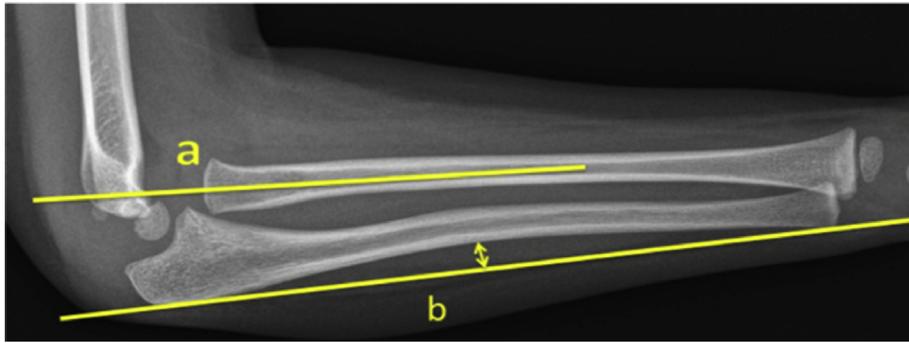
Lateral radiograph of a Monteggia fracture. Radiocapitellar line (a) passing above the radial head on this lateral view. Ulnar bow (b) which is normally rectilinear and apex posterior, is now shown reversed indicating plastic deformation and should raise the possibility of this injury to be more complex than it seems.³³ Reproduced from reference 18 with permission from Elsevier.
